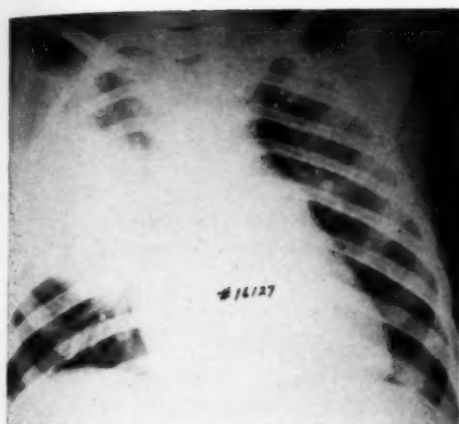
Lobar pneumonia; 200 roentgens to anterior chest immediately after admission, followed by clinical improvement. Temperature normal on fourth hospital day.
